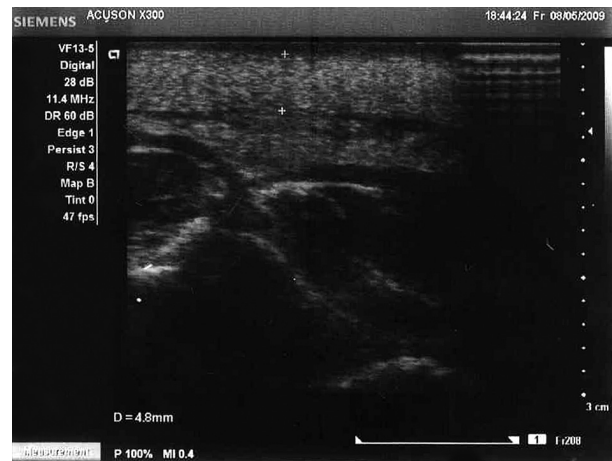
The ultrasound scan demonstrates a homogeneously hyperechogenic subcutaneous tissue thickened up to 6 mm
